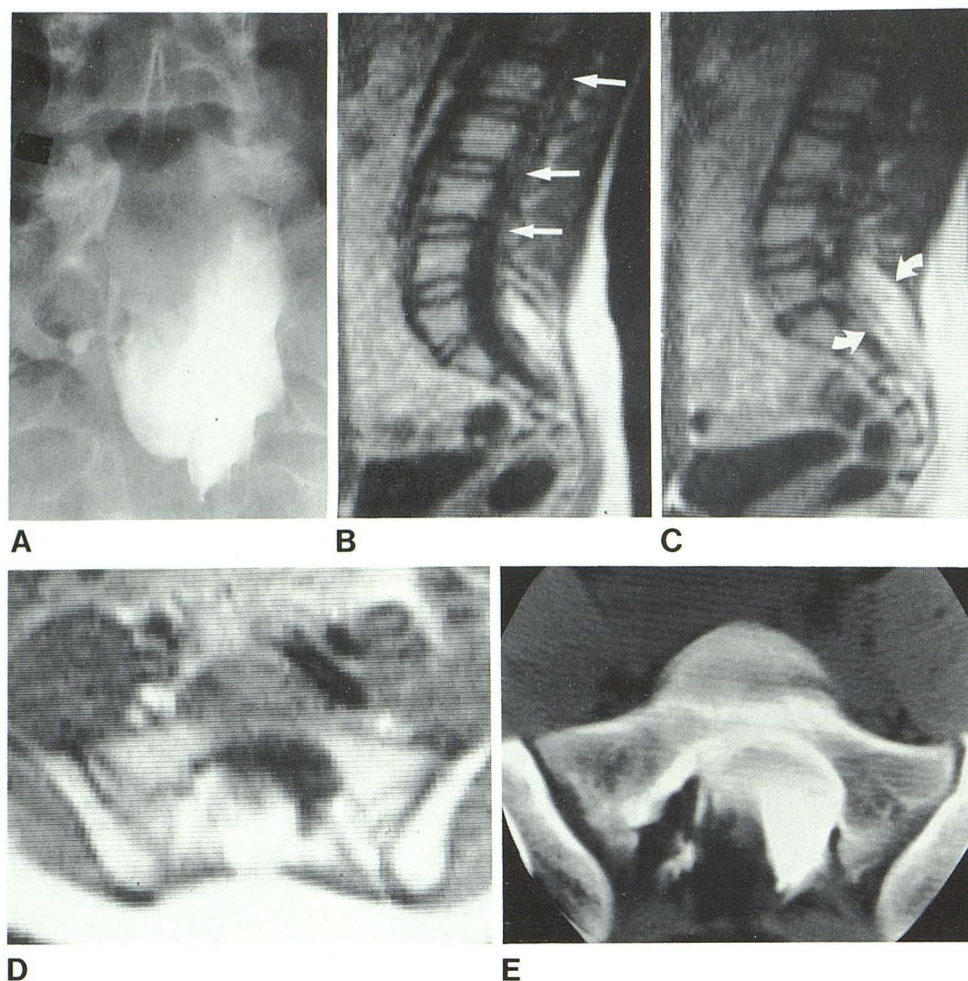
Spinal dysraphism in 15-year-old boy. A, Metrizamide myelogram. Separation of low-lying spinal cord from lipoma is impossible on myelogram. Superior extent of lipoma was not apparent because of rapid dilution of metrizamide in capacious subarachnoid space. B, Sagittal SR image shows low-lying spinal cord along posterior aspect of capacious thecal sac (arrows). C, Parasagittal image toward right side shows larger part of lipoma (arrows). Pedicles and intervertebral foramina at L3 level through S1 are seen clearly in this image plane. D, Axial NMR image at S1 level shows composition of intra- and extradural lipoma. E, CT scan after myelography shows nearly identical configuration of intra- and extradural lipoma, as in NMR images. With NMR, white intensity represents fat and black is CSF; with CT, white density is CSF mixed with metrizamide, and black is fat.
